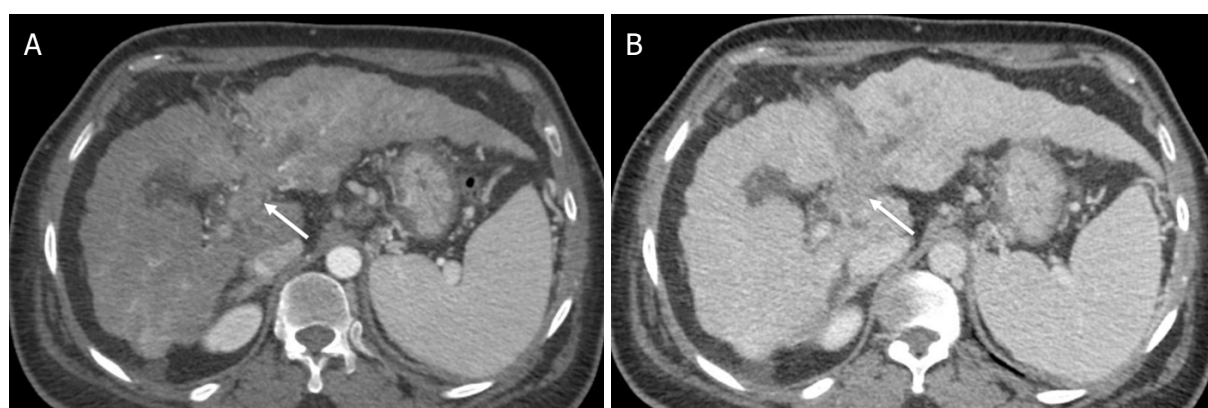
LR-TIV (Definite tumor in vein). Axial computed tomography in a 63-year-old woman with hepatitis C cirrhosis. Arterial phase (A); and portal venous phase (B) demonstrate definite enhancing soft tissue extending to the left portal vein (arrow). The observation is categorized LR-TIV. Note that the presence of parenchymal mass is not required for this category
